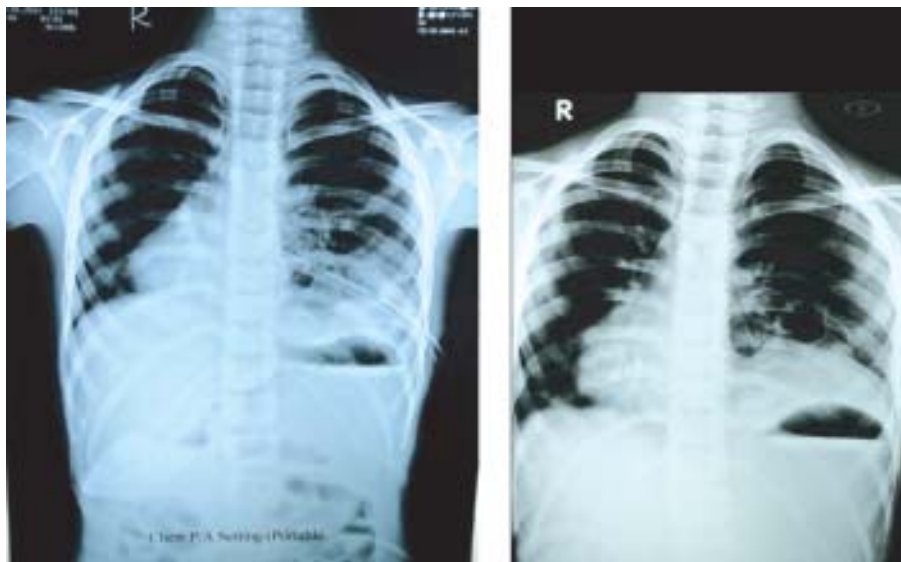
Post operative day chest radiographs before and after removal of chest drain tube showing extend of lung expansion.
